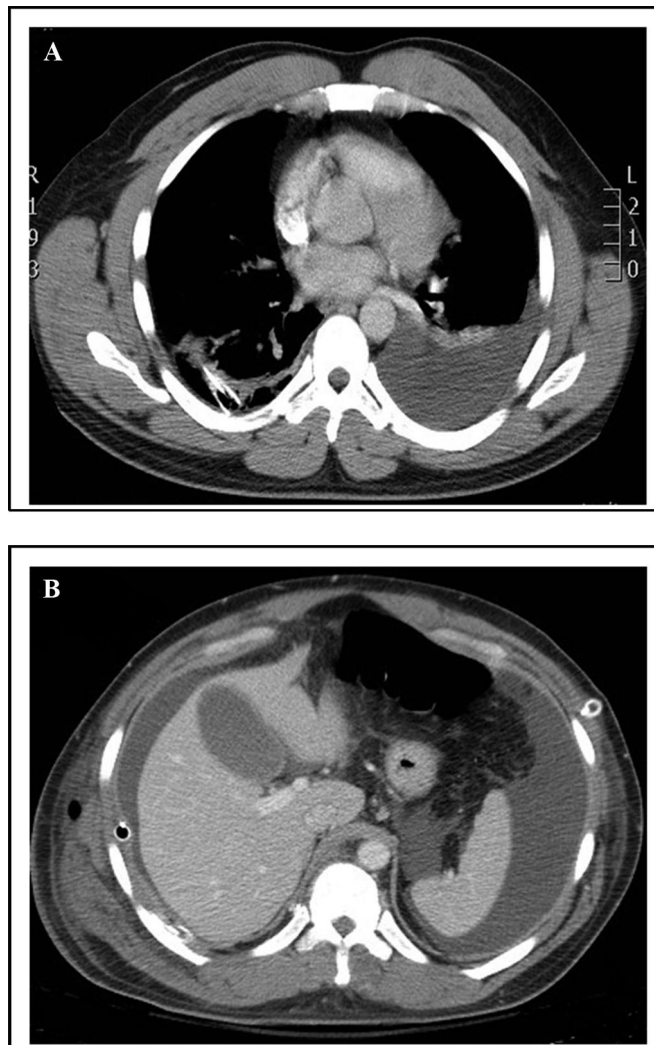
CT imaging at the time of presentation, demonstrating (a) pleural effusions and (b) ascites.
